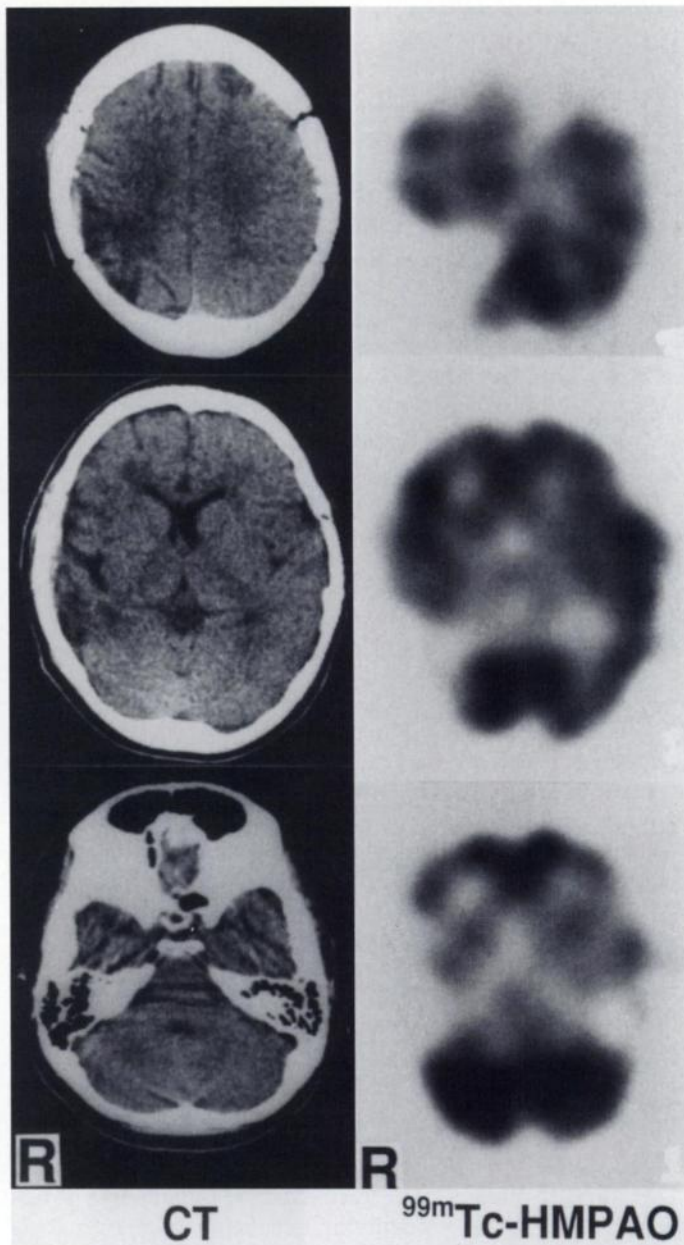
Technetium-99m-HMPAO brain SPECT images reveal no abnormality in cerebral blood flow, except in regions imaged as low density areas on brain CT (right). Radiograph CT scans demonstrate low density areas in the right temporal, parietal and left frontal areas (left).
